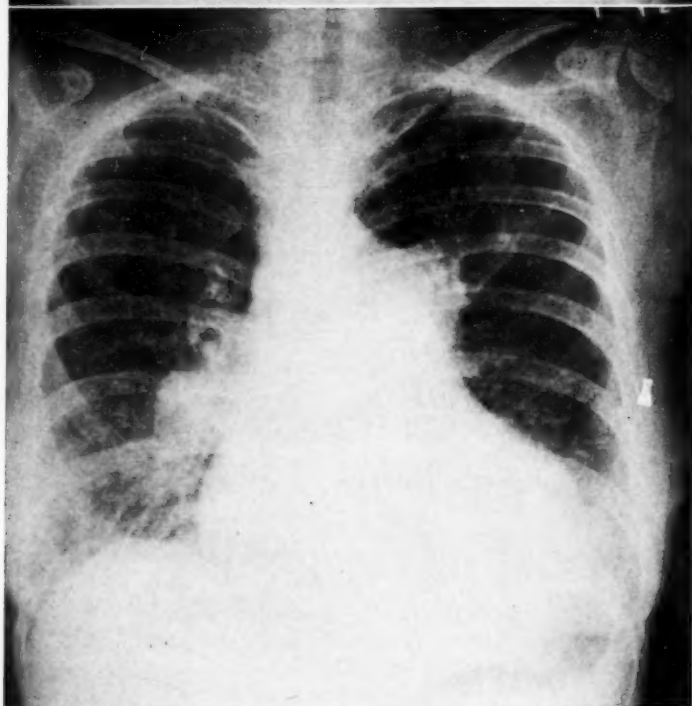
Case 2. Posteroanterior roentgenogram of the chest taken 4 years prior to the patient's death.
